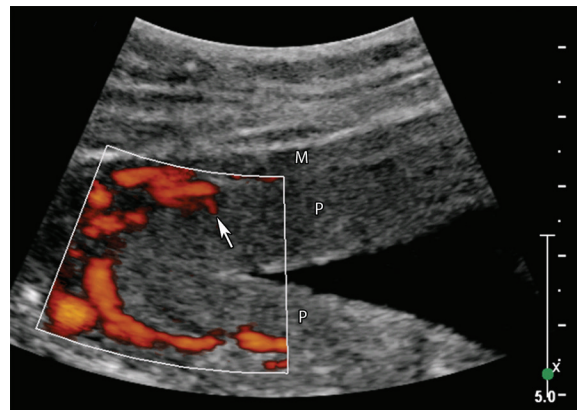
Normal placenta at 12 weeks gestation. Transverse color Doppler image shows intervillous flow (arrow). *M* = myometrium, *P* = placenta.
